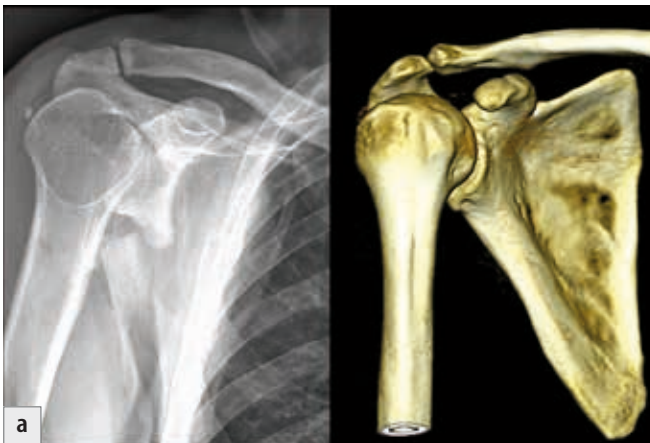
Anteroposterior view of the shoulder: a) radiograph and CT reconstruction; b) position of the scapula and the X-ray cassette.
